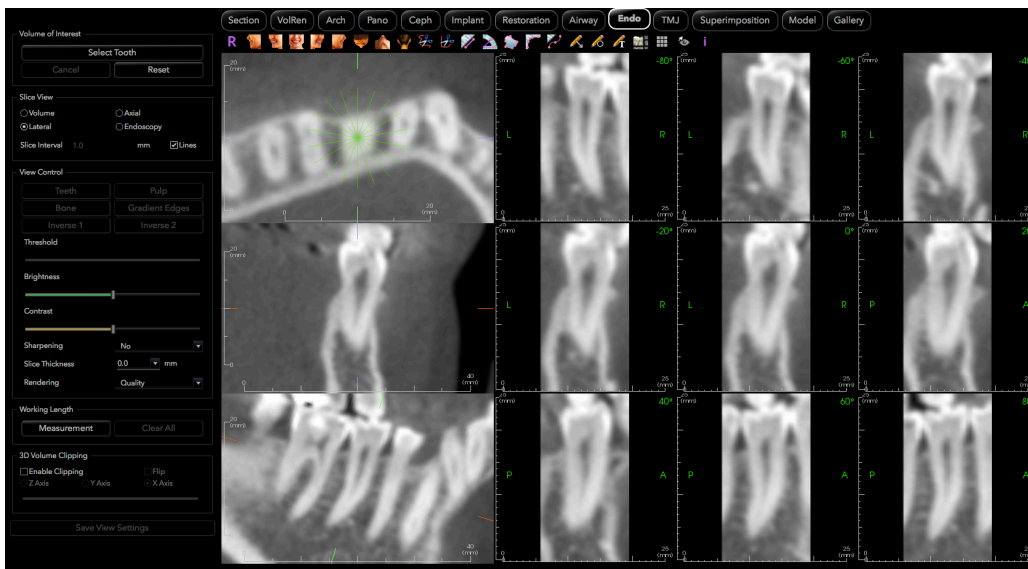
Reformatted CBCT image using the Endo module, which enables a cross-sectional image of the tooth to be seen. Sagittal view for anterior teeth and coronal section for the posterior teeth InVivoMac, Version 6.0.3 software (Anatomage, San Jose, CA)
